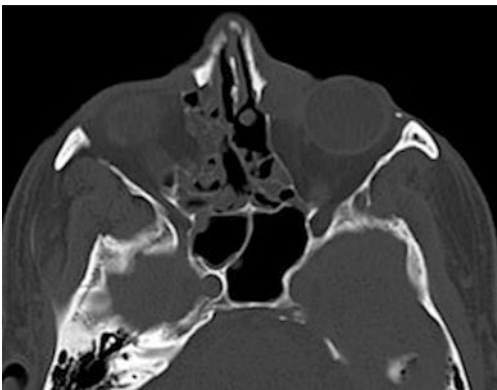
Bilateral naso-ethmoidal complex fracture. Axial non-enhanced CT image demonstrates bilateral multiple comminuted fractures of the nasal bones, ethmoid air cells and medial wall of both orbits as well as fracture of the nasal septum
